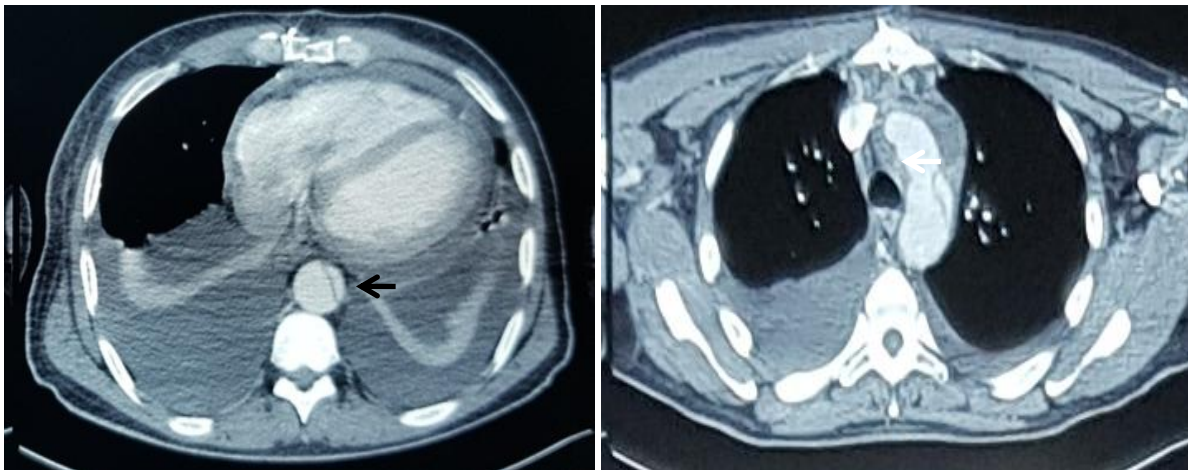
Computed tomography scan with contrast with transverse plane showing dissection across the thoracic aorta (arrows).
